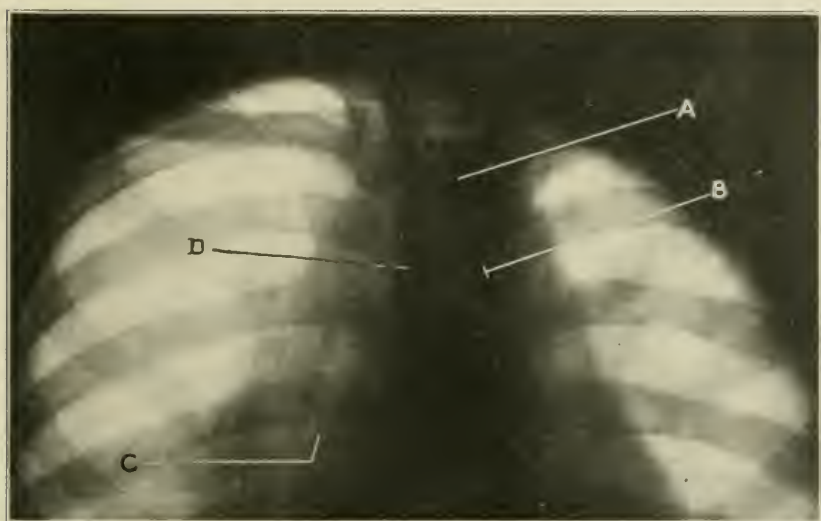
Roentgen ray of Helen A. (Case 1). Bifurcation trachea at *D*. Left border of trachea (*A*), left border of left bronchus (*B*). The extensive lesion at the right hilum is seen to the right of the heart whose right border is indicated by the inner end of line (*C*). Compare with physical signs and necropsy findings.
